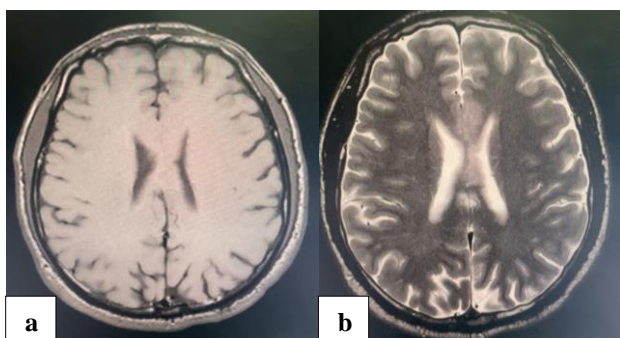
Axial cut MRI T1 was normal and T2 sequence showing isointensities at the body of the corpus callosum.
